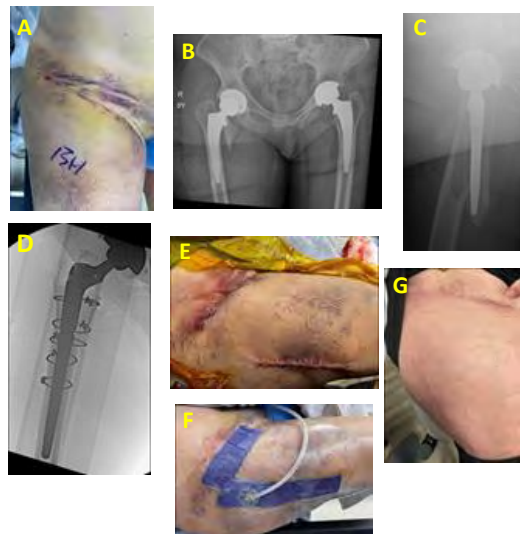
Case Example: Femoral Periprosthetic Fracture Managed through Bikini Incision and Accessory Lateral Incision. (A) Initial bikini incision. (B-C) Acute femoral periprosthetic fracture on AP and lateral view radiographs. (D) Intraoperative radiograph demonstrating fracture fixation with cerclage wiring. (E) Immediate postoperative closure of both the concordant bikini incision and the fresh accessory lateral incision. (F) Postoperative negative pressure wound dressing. (G) Well-healed incisions at follow-up.
